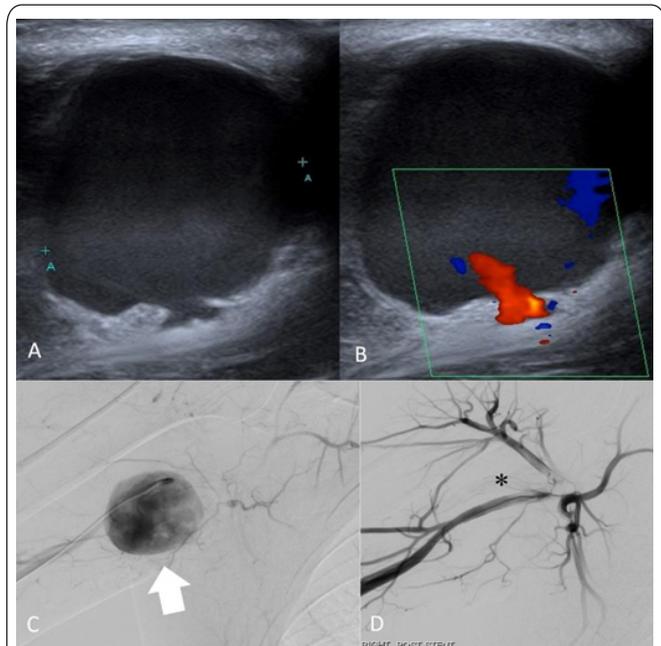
Targeted ultrasound interrogation of the right axilla demonstrates a right brachial artery pseudoaneurysm which measures 45 x 30 x 35 mm, and devoid of a neck (Images A and B). The pseudoaneurysm abuts and exerts mass effect onto the adjacent brachial nerve. The intra-operative angiogram demonstrates the pseudoaneurysm [Image C – (arrow)] and a covered stent was subsequently deployed across the pseudoaneurysm neck [Image D – (asterisk)]. This aided the subsequently performed wound exploration and washout.
